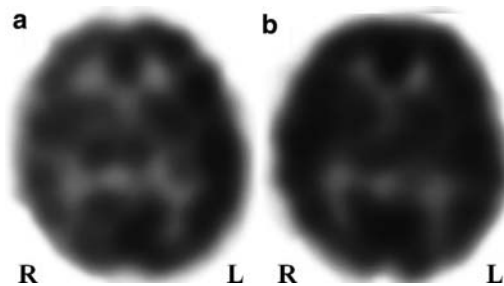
(a) Preoperative and (b) postoperative (3 months) SPECT. Preoperatively, the CBF is decreased in the right (R) hemisphere and the postoperative image shows marked improvement
